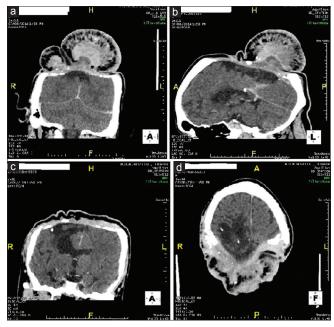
Contrast-enhanced computed tomography image in coronal (a and b), sagittal (c) and axial plane (d) shows bony gap, intracranial gliotic changes in bilateral parafalcine and right occipitoparietal region with dystrophic calcific foci and enhancing soft tissue density mass lesion in midline parietal scalp swelling without any evidence of intracranial enhancing mass
